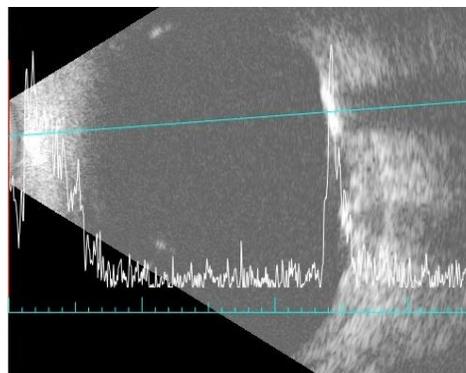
B-Scan ultrasonography of the right eye showing hyperechoic foci with posterior shadowing, consistent with calcifications. There is high internal reflectivity noted on the superimposed A-scan.
